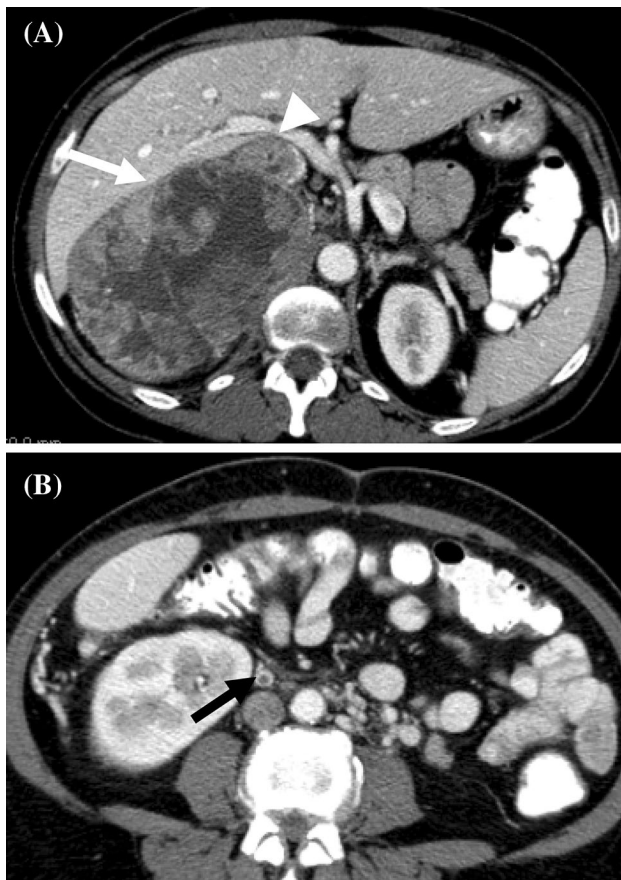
A 59-year-old woman with ACC. Axial contrast-enhanced abdominal CT (a and b) shows large heterogeneously enhancing right suprarenal mass (white arrow) with enhancing tumor thrombus extending into the Inferior vena cava (white arrowhead) and luminal defect within the right gonadal vein indicating thrombosis (black arrow)
